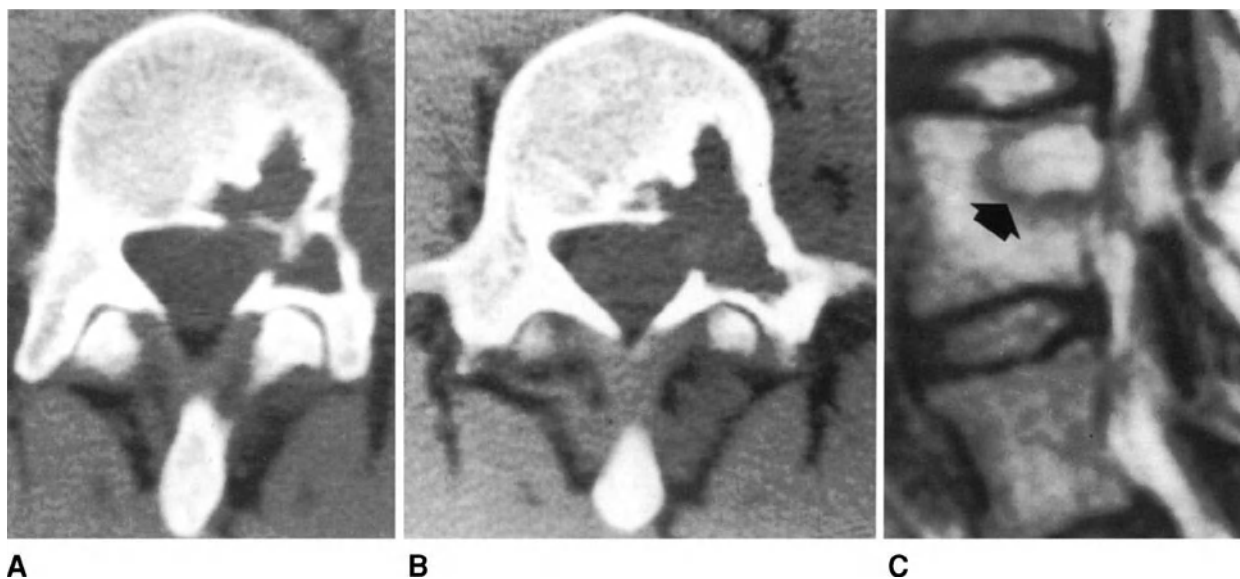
Eosinophilic granuloma in the vertebral body and left pedicle of L4. CT scans (A) and (B) show an osteolytic area interrupting the cortical bone delimiting the spinal canal anterolaterally. In the vertebral body, the lesion is surrounded by a rim of sclerotic bone. On the turbo T2-weighted image (C), the lesion appears hyperintense and encircled by a rim of low signal intensity resulting from bone sclerosis (arrow). The remainder of the vertebral body is hyperintense due to edema of the trabecular bone.
